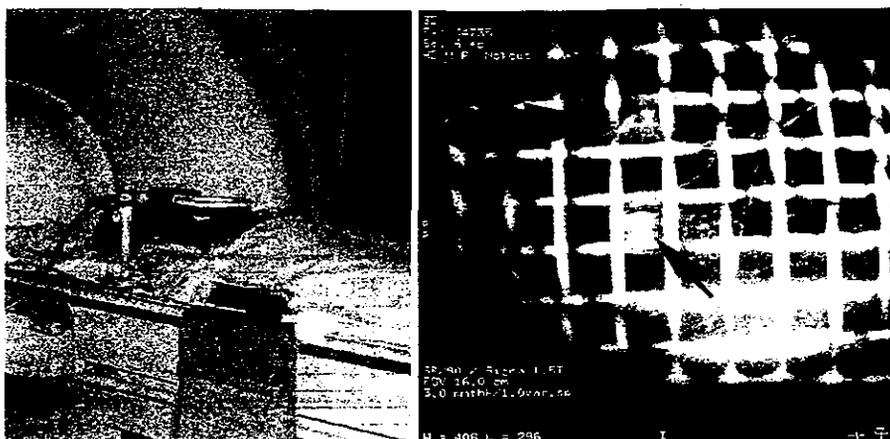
3D MRI navigation using a specialized mapping sheet. The patient is placed in the supine position (A). The grids containing the tumor (a large arrow) are marked on the skin (B). A small arrow indicates the nipple.
